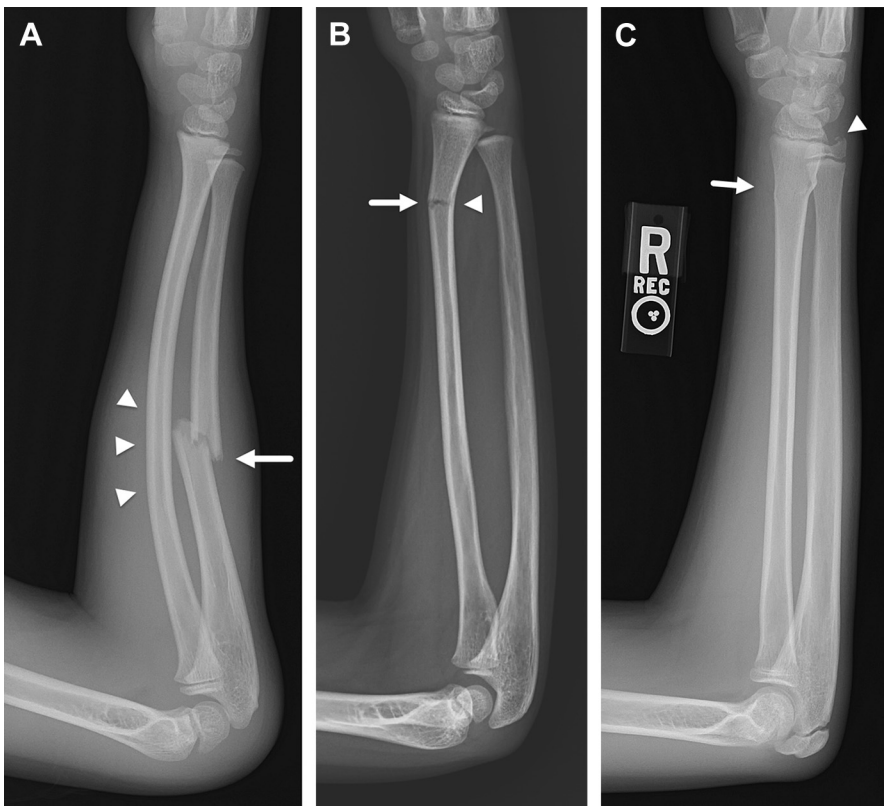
Long bone fractures in children. (A) Lateral radiograph of the forearm shows plastic deformation of the radius (*arrowheads*) and transverse fracture of the ulnar midshaft (*arrow*). (B) Lateral radiograph of the forearm shows greenstick fracture of the distal radial shaft with cortical disruption at the radial side (*arrow*) and plastic bowing of the ulnar side (*arrowhead*). (C) Lateral radiograph of the forearm shows buckle fracture of the distal radius metadiaphysis (*arrow*) and ulnar styloid avulsion fracture (*arrowhead*).
